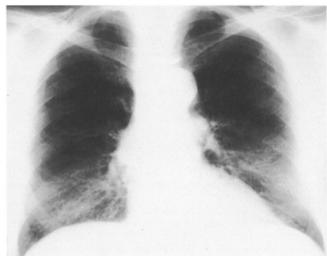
A 57 year old female smoking 15–20 cigarettes per day for 27 years. Radiograph (a), and CT (b), demonstrate the proliferative lung changes classified as a cluster of CT findings: peribronchial thickening, interlobular thickening, ground-glass attenuation, and bronchial carcinoma of the right lung.
